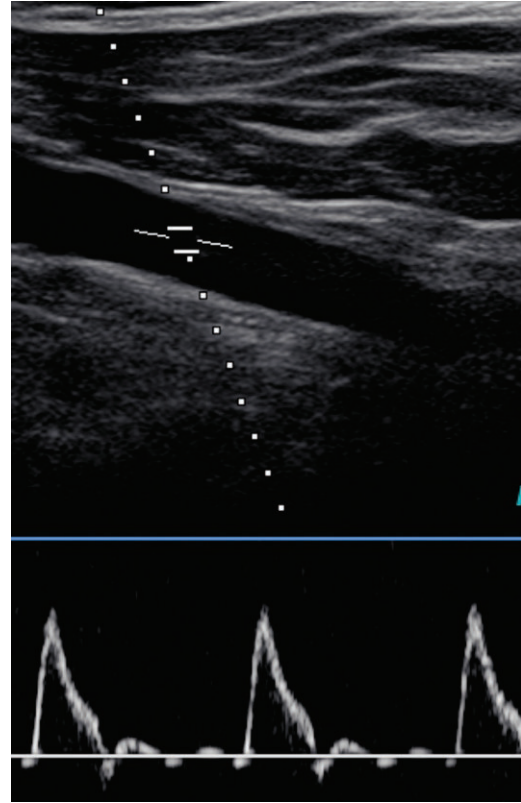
Spectral Doppler of the subclavian artery demonstrates normal waveform shape without spectral broadening when the sample volume size is set to the correct size.
